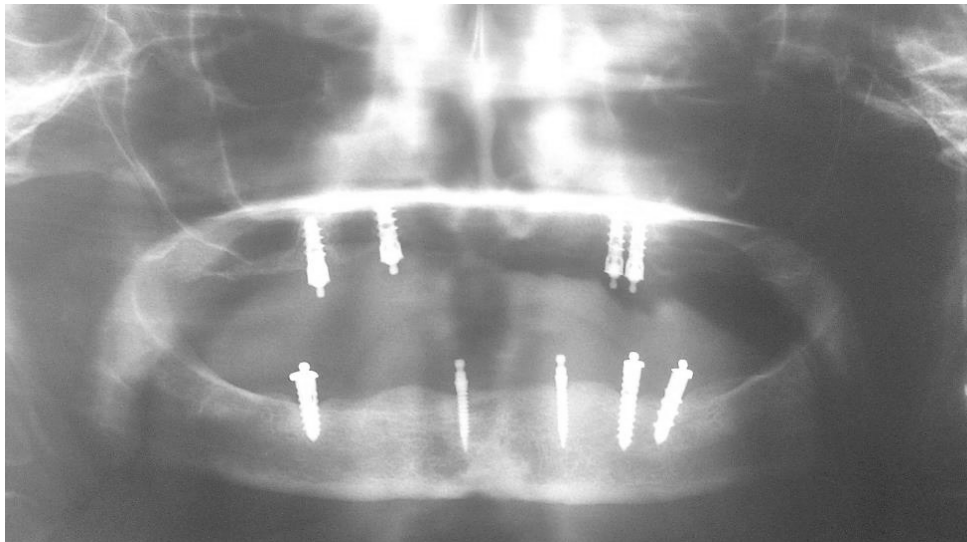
Panoramic X-ray after inserting new implants: 2 one-piece implants were used in the mandible.*
